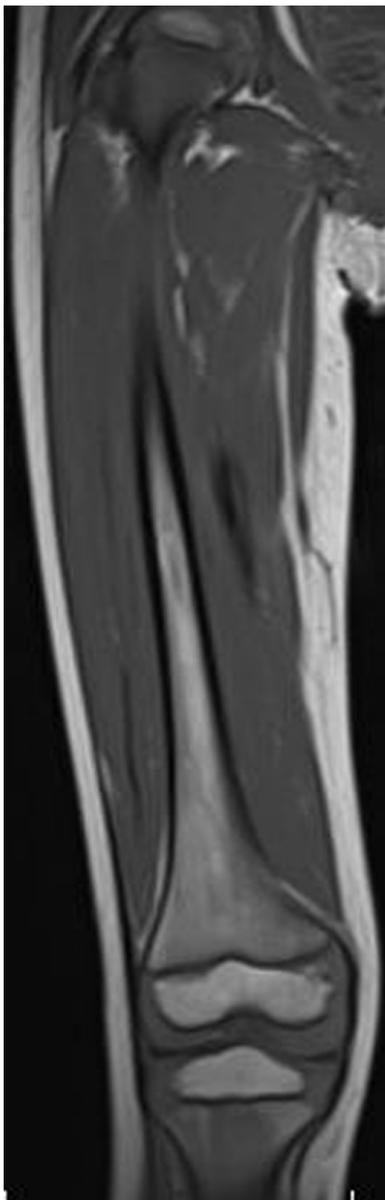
Coronal T1 magnetic resonance imaging scan of the right femur.
